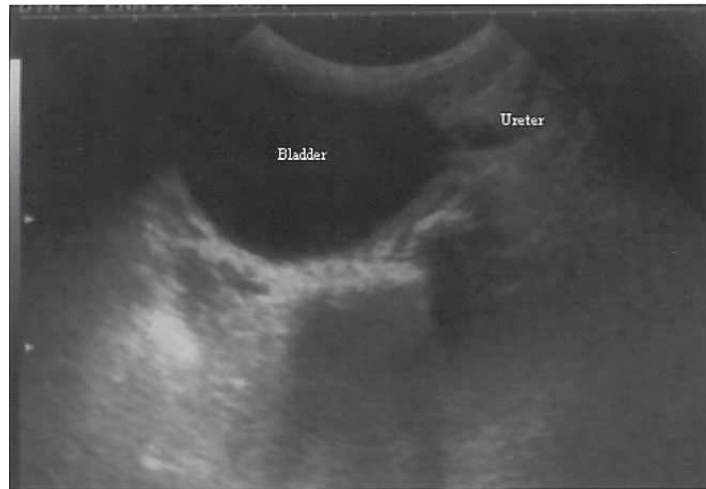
Ultrasound scan shows a longitudinal view of a megaureter.
